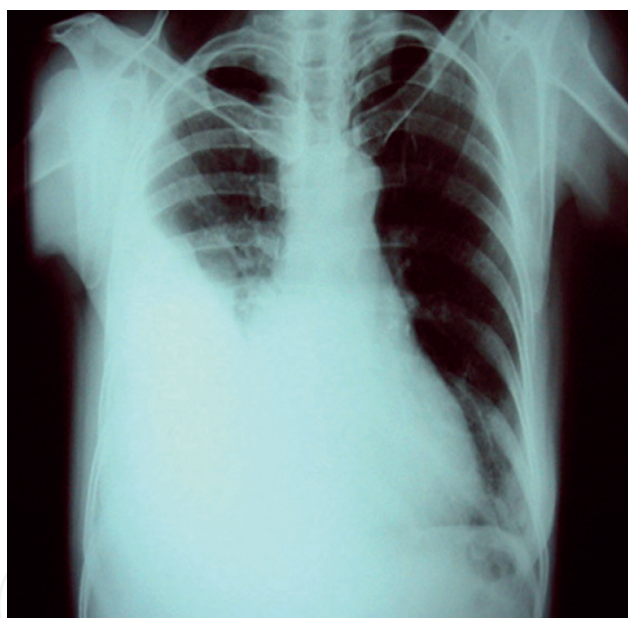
Left thoracoplasty X-ray image.
